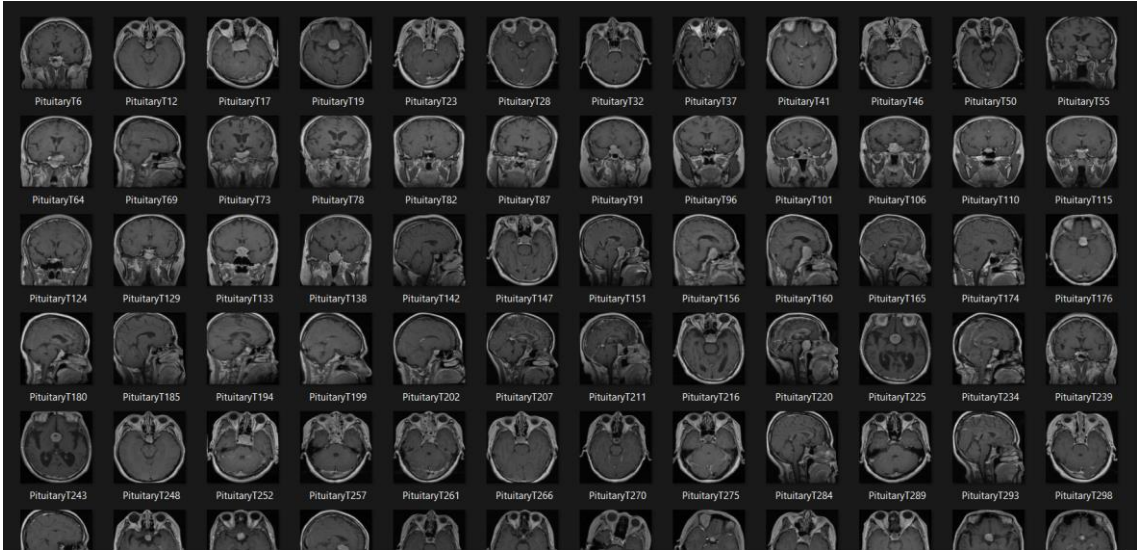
Pituitary Tumour Brain MRI
